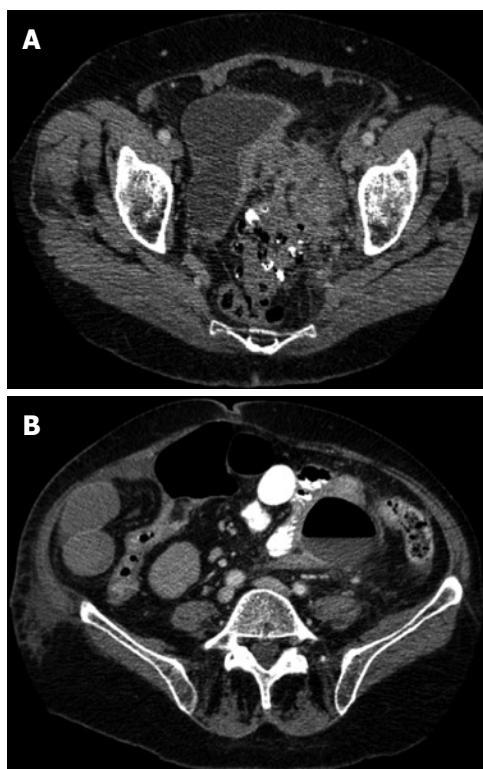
Abdomen and pelvis CT. A: Pelvic abscess secondary to complicated diverticulitis; B: Paracolic abscess secondary to complicated diverticulitis.
